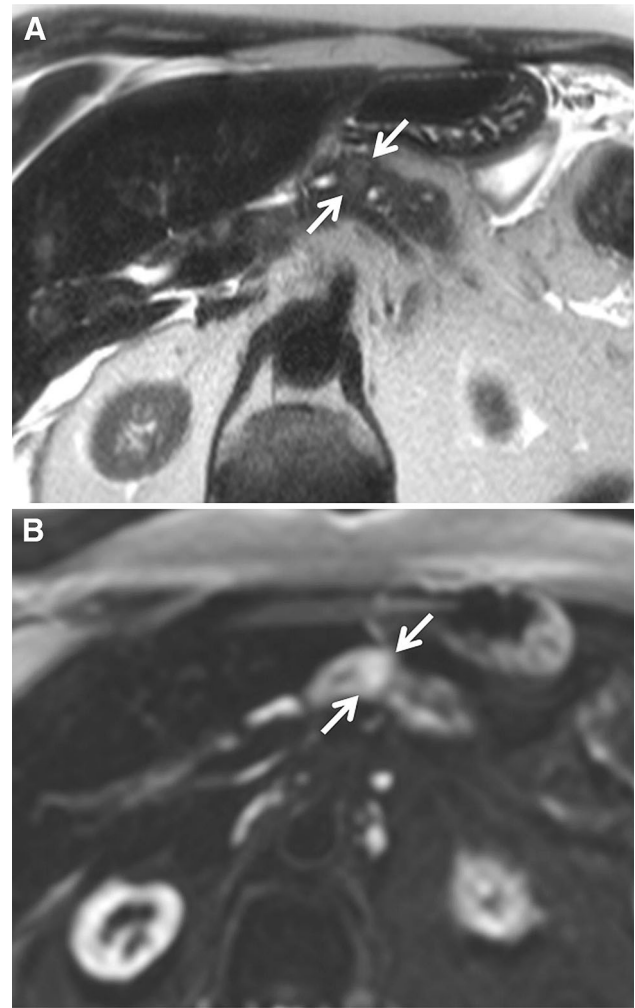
Axial T2 weighted image (A) demonstrating a small area of subtly increased T2 signal (arrows) without significant associated ductal dilatation. Axial high *b*-value diffusion weighted image (B) shows a corresponding area of increased diffusion signal (arrows). Decreased signal on the associated attenuation diffusion coefficient (ADC) map confirmed true diffusion restriction (not shown). Subsequent endoscopic ultrasound (EUS) and distal pancreatectomy yielded ductal adenocarcinoma.
